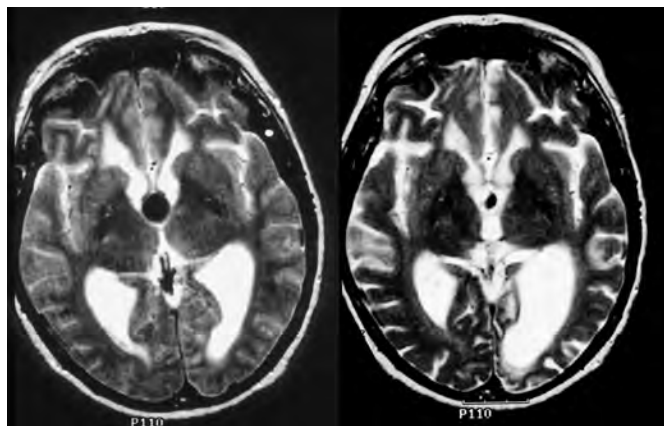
Post-operative (left) and 9 month follow-up (right) axial T2 weighted MR images of patient E3. Predominantly calcified cyst contents resulted in an incomplete resection of her colloid cyst (left). Follow-up image at 9 months (right) demonstrated a reduction in size of cyst contents.
